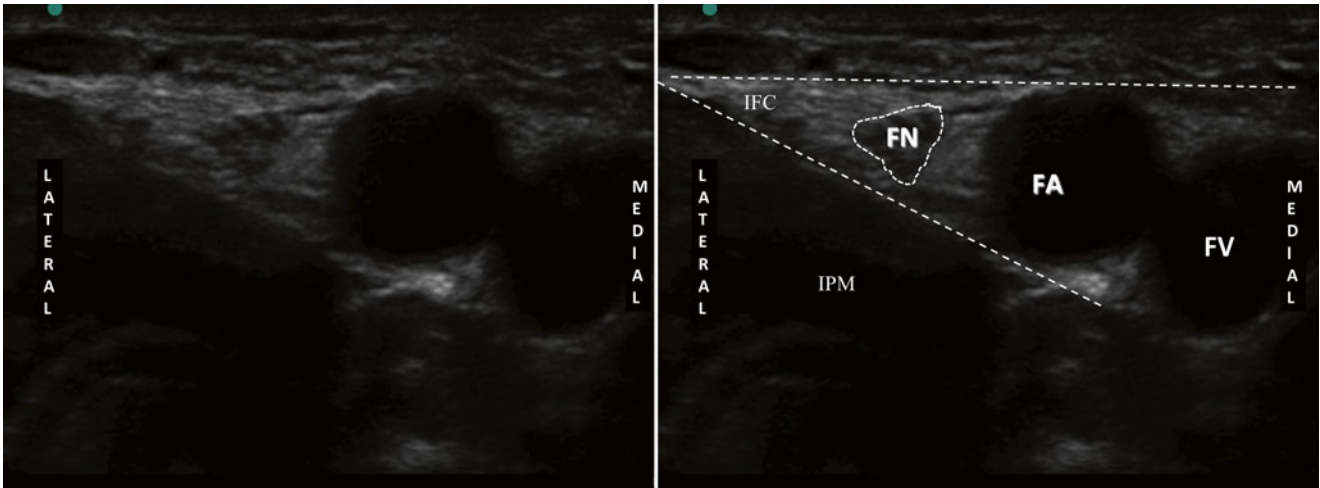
Ultrasound image of the femoral nerve. *FA* femoral artery, *FV* femoral vein, *IPM* iliopsoas muscle, *IFC* iliac fascial compartment (Image courtesy of Thiago Nouer Frederico, MD)
